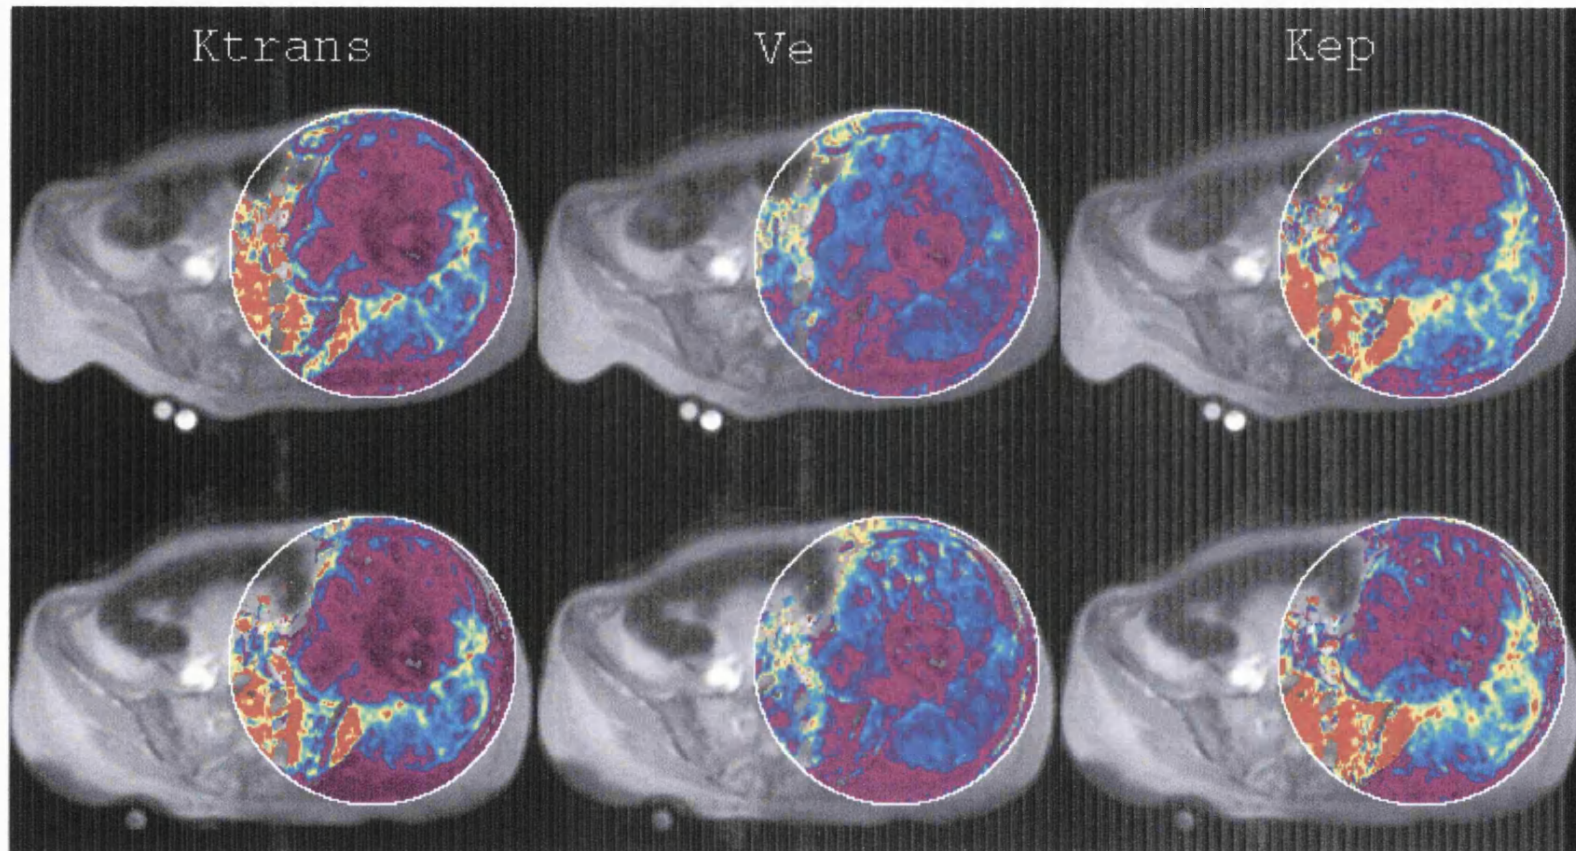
Paired pre-treatment MR images with parametric maps from patient 15. These axial images through the pelvic area demonstrate a large leiomyosarcoma metastatic to the left iliac bone. A circular ROI is shown within which parameter maps are displayed. The colour scale is displayed on the right in ml/ml/min. These images demonstrate excellent spatial reproducibility within the tumour and surrounding normal tissues
